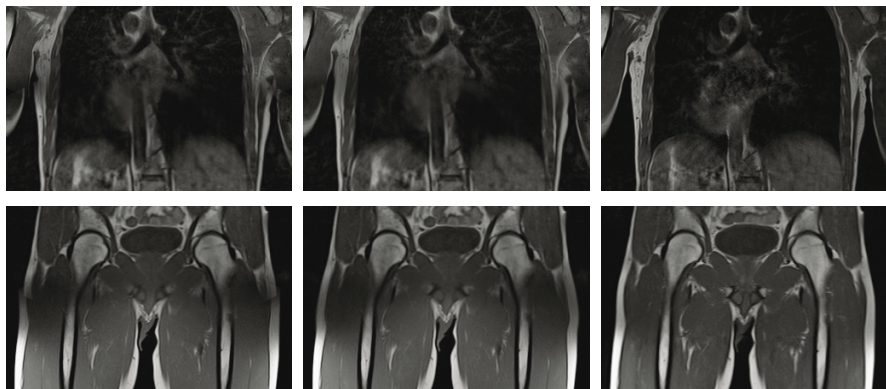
The two rows are magnifications of the stitching areas of the WB-MRI shown in Fig. 1. Left: Initial average. Middle: Final stitching result after 3 optimization cycles. Right: Reference scan where the overlap volume is centered within the MR scanner. Our method is able to reproduce similar smooth and continuous transitions as present in the reference images.
